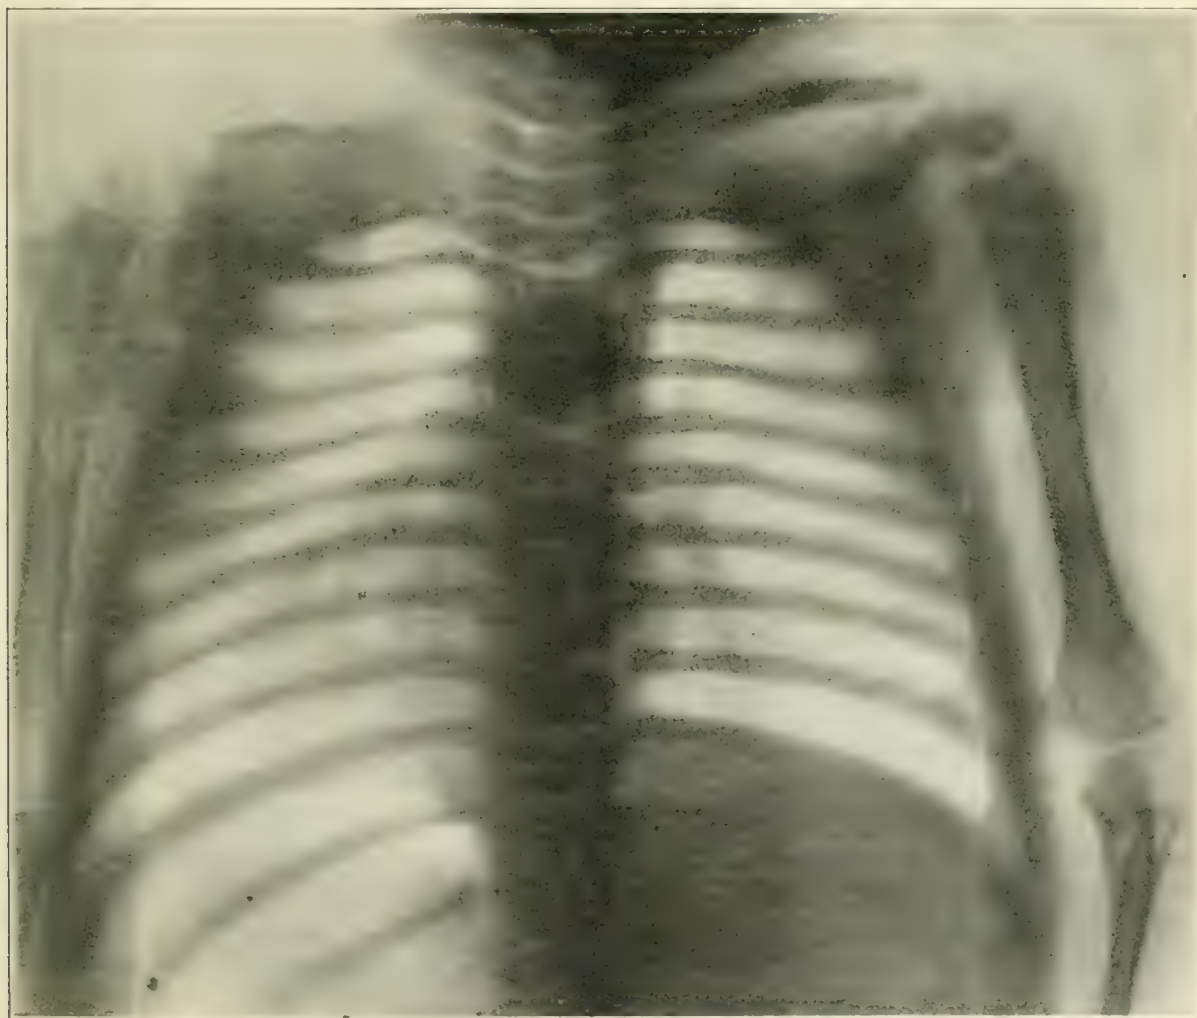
Radiograph showing position of the coin in the oesophagus
